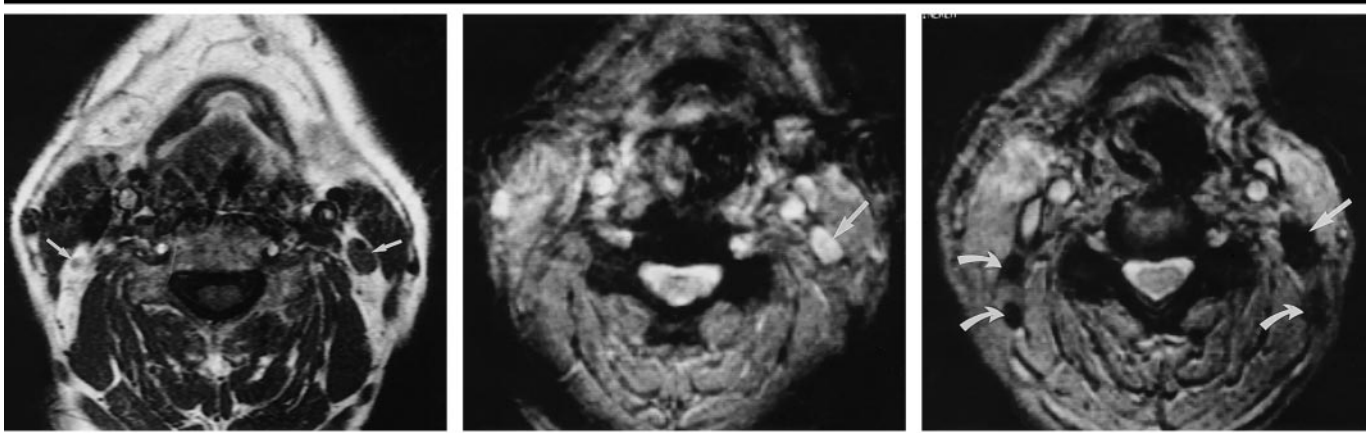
(a) Transverse nonenhanced T1-weighted SE image (500/15) shows a lymph node in level II on the left side (right arrow) and another lymph node in level II on the right side (left arrow). (b) Transverse nonenhanced T2-weighted GRE image (500/15, 15° flip angle) demonstrates the lymph node (arrow) in level II on the left side, with hyperintense signal pattern. The lymph node in level II on the right side is hard to delineate. (c) Transverse SPIO-enhanced T2-weighted GRE image (500/15, 15° flip angle) demonstrates SI decrease in the lymph node (straight arrow) in level II on the left side and a better visualization of the lymph nodes on both sides (curved arrows), which represents reactive lymph nodes.
